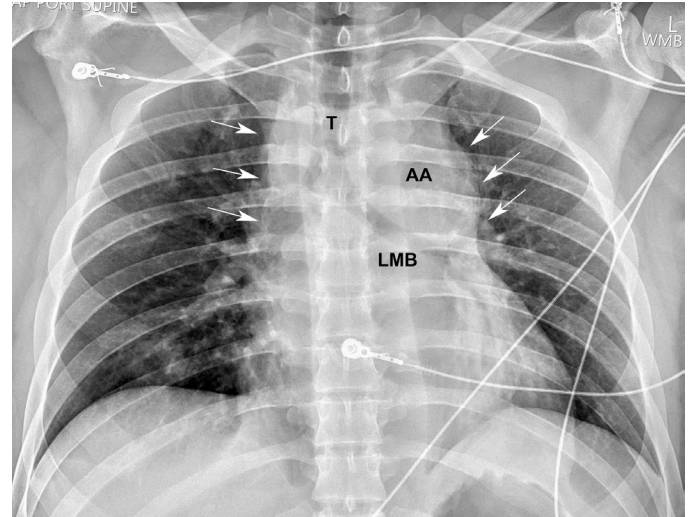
■ Anteroposterior (AP) supine chest x-ray. Traumatic aortic transection or “tear,” resulting in a wide mediastinum (white arrows) with an indistinct aortic arch (AA), depression of left main stem bronchus (LMB), and deviation of the trachea (T) to the right.
